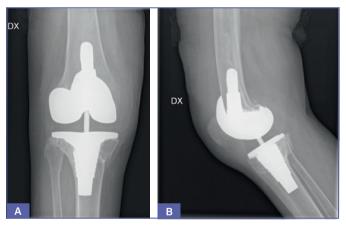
A) 3 months follow-up x-ray AP view; B) 3 months follow-up x-ray lateral view.
